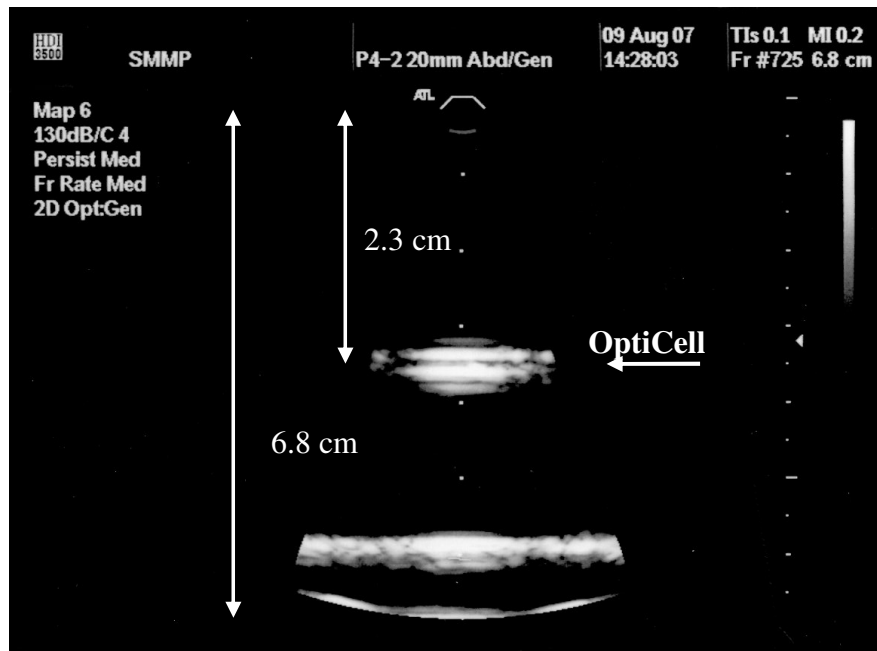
Representation of monitor from ultrasound scanner HDI3500. During sonoporation experiments with the ultrasound scanner, OptiCells™ were placed at the focal point of the beam, shown by the small arrow on the right hand side of the image. Distance from probe to bottom of the tank is 6.8 cm, while the focal point is around 2.5-3 cm below the probe. A range of mechanical and thermal indexes were used in order to establish sonoporation of cells. Top image MI=0.2, TI=0.1 and bottom image MI=0.5, TI=0.3.
